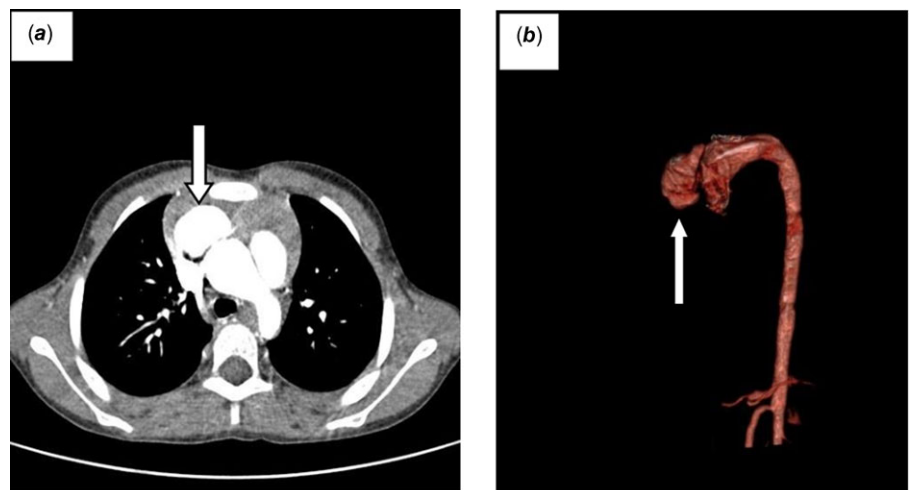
(a,b) Pre-operative CT angiography image of the aorta.
